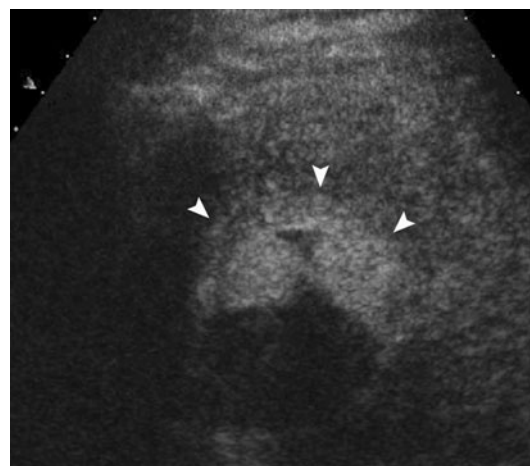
Hepatic HCC treated with ablation. Contrast-enhanced ultrasonography at the arterial phase obtained after treatment. Residual tumoral area shows evident uptake of intravenous contrast (arrowheads) while the necrotic area do not enhances.
